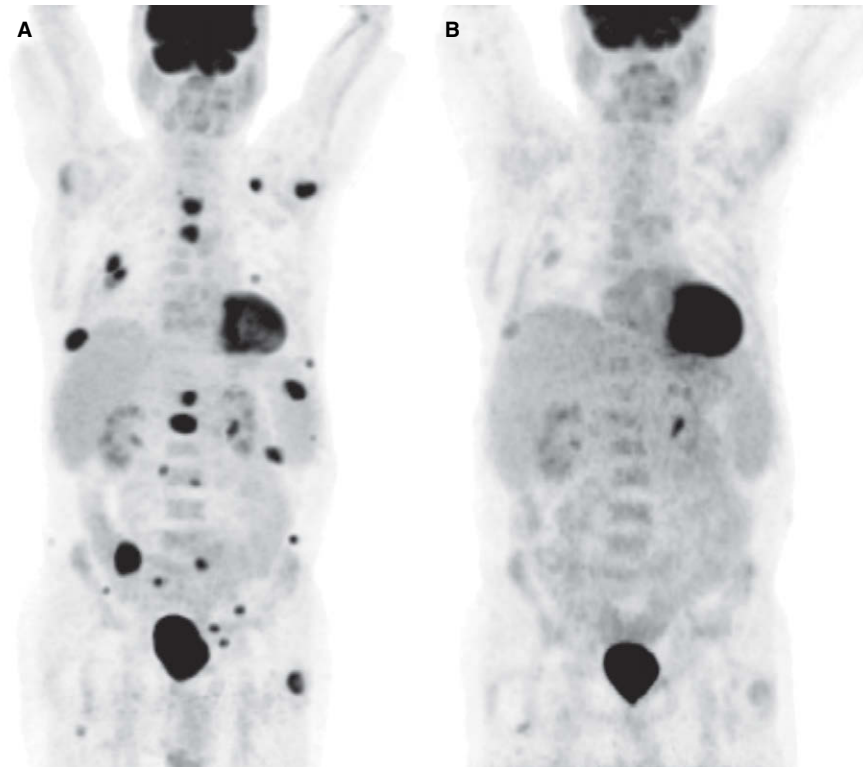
A 70-year-old man with newly diagnosed melanoma on his back. (A) Initial staging PET-CT found multiple bony and soft tissue metastases. BRAFV600E mutation was found on biopsy. (B) Follow up PET-CT after 2 months treatment with a BRAF inhibitor found a dramatic decrease in FDG uptake, although the morphological findings were unchanged on CT (not shown).
